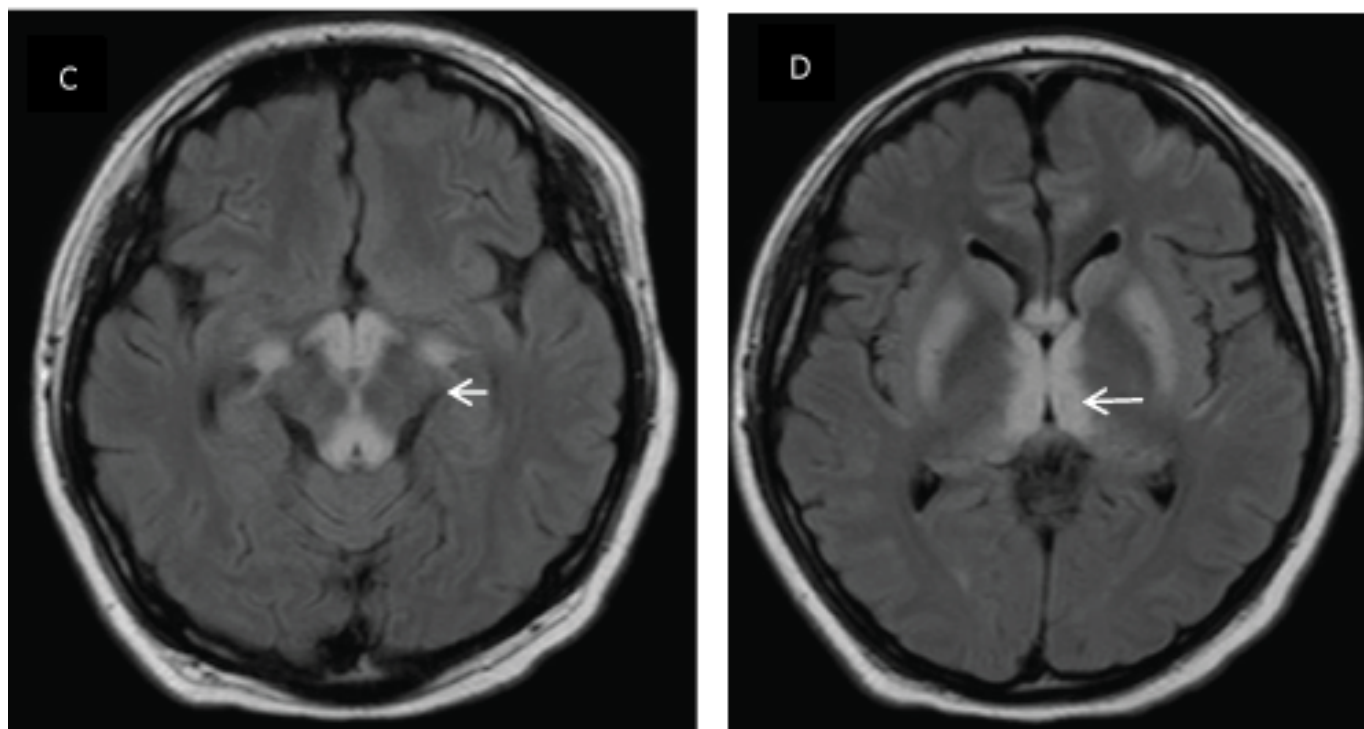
(C,D): Brain MRI follow-up at 4 days shows bilateral extending basal ganglia (putamen) and brain cortex hyper intense lesions with accentuation in cuadrigeminal tuberculosus and thalamus.
